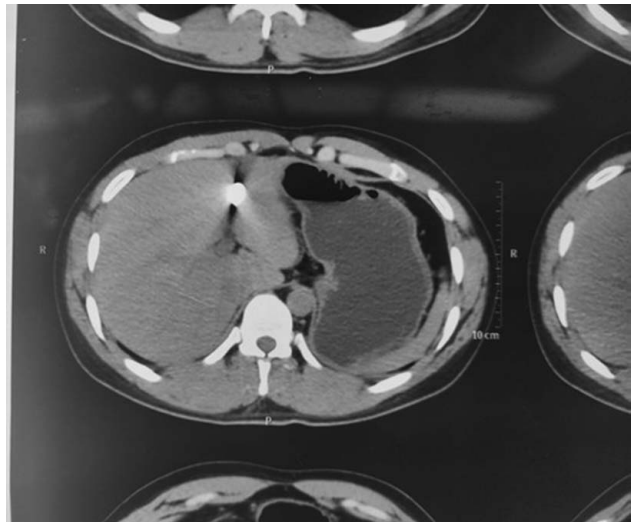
Contrast Enhanced Computed Tomography (CECT) of the abdomen showing a metallic foreign body measuring approximately $7 \times 12 \times 16$ mm located in segment II of the liver
